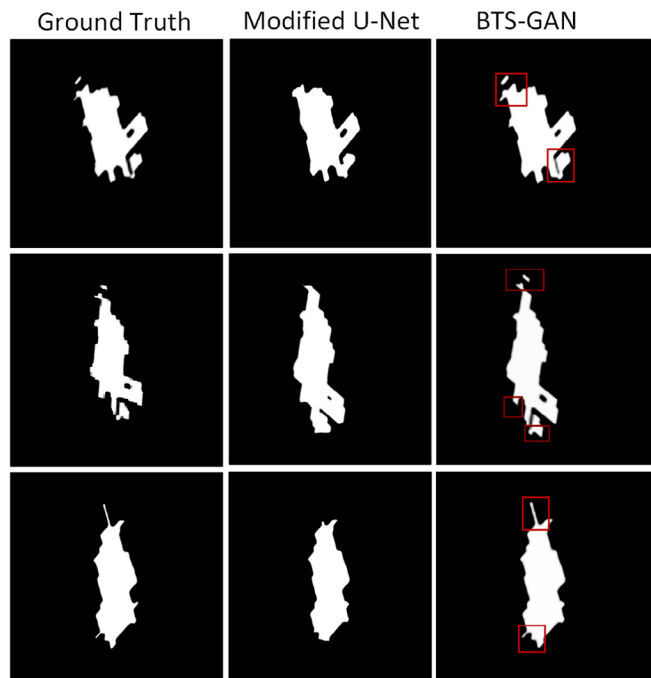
Comparative results of the modified U-Net and the BTS-GAN on three MRI scans (results are zoomed out for clear demonstration).
